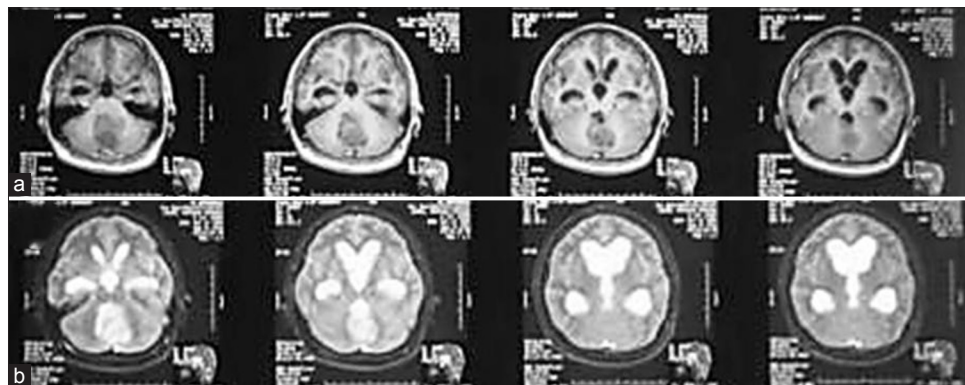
Magnetic resonance imaging of the head without contrast (a) and with contrast was performed (b), which showed a posterior fossa mass that enhanced inhomogenously, as well as noncommunicating hydrocephalus
